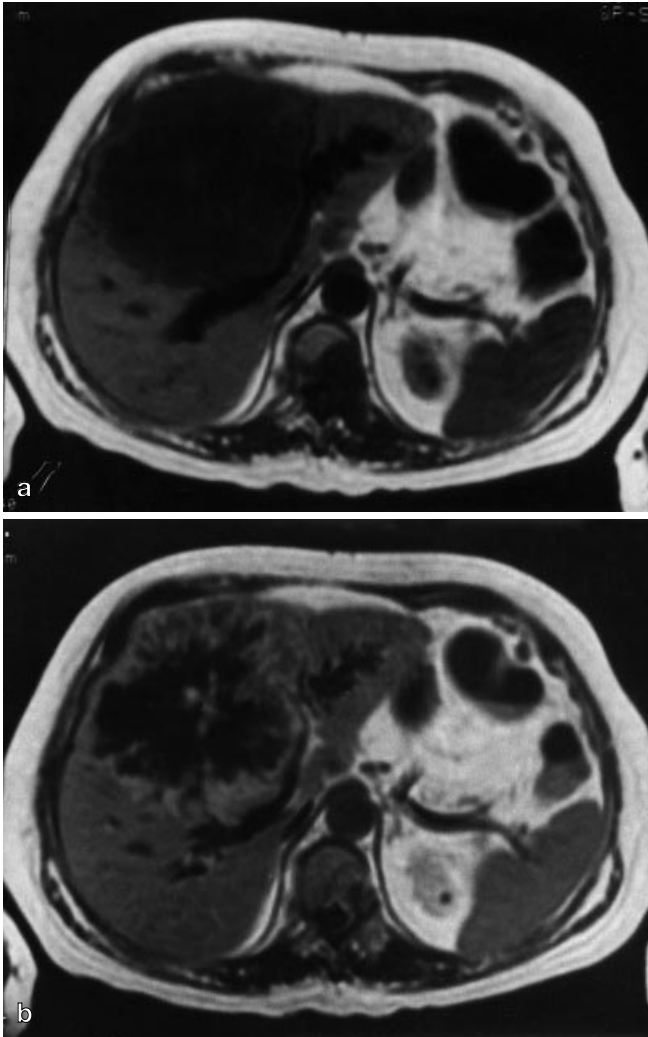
Angiosarcoma. a The tumor is hypointense to liver on the T1-weighted image. b Inhomogeneous peripheral enhancement, without nodular pattern, is seen on the gadolinium-enhanced image
